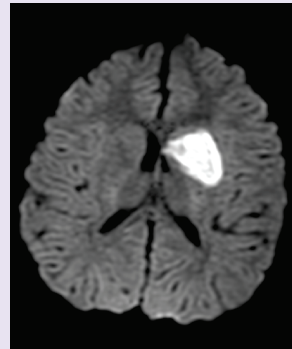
Infarct in left basal ganglia and anterior limb of internal capsule in DWI
